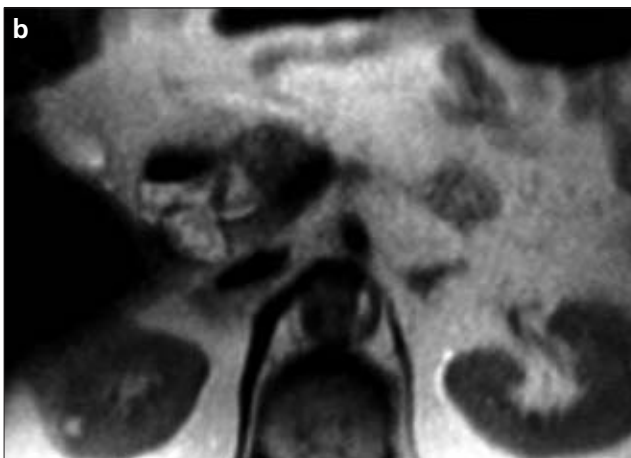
a–c. Contrast enhanced CT (a), HASTE T2-weighted MR (b), and contrast enhanced FLASH T1-weighted MR (c) images of a solitary metastasis in the neck of the pancreas, with rim enhancement and intermediate signal intensity on the HASTE T2-weighted MR image (b), in a 72-year-old patient with lung adenocarcinoma.
